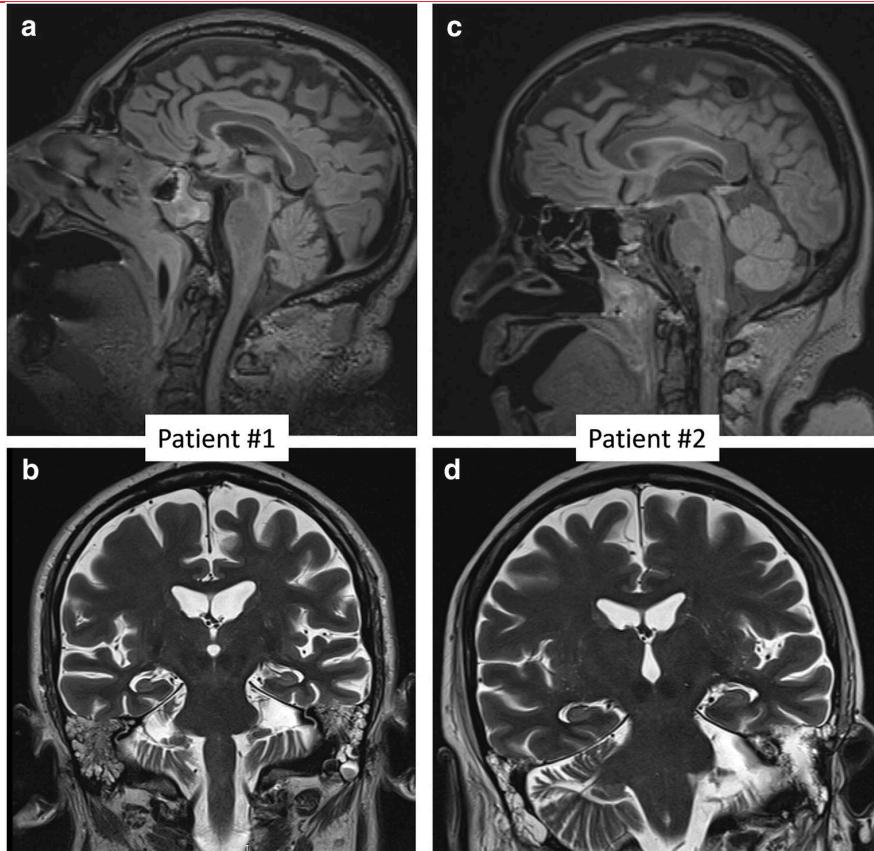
Brain MRI sagittal FLAIR (a, c) and coronal T2-weighted (b, d) images from patient #1 (a, b) and #2 (c, d). No structural changes are visible
